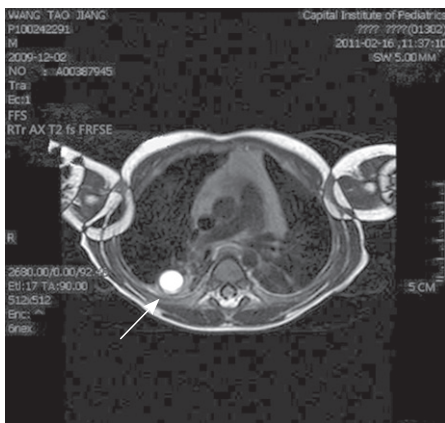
Chest MRI showing a round lesion in the lower lobe of the right lung (arrow). T2 weighted MRI images with fat suppression revealed a high signal.
